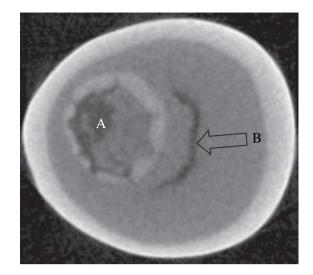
Axial computed tomography scan of an extracted tooth showing the invagination (a) with eight separate interruptions in the enamel layer (A). The pulp (B) is compressed by the presence of the invagination.
